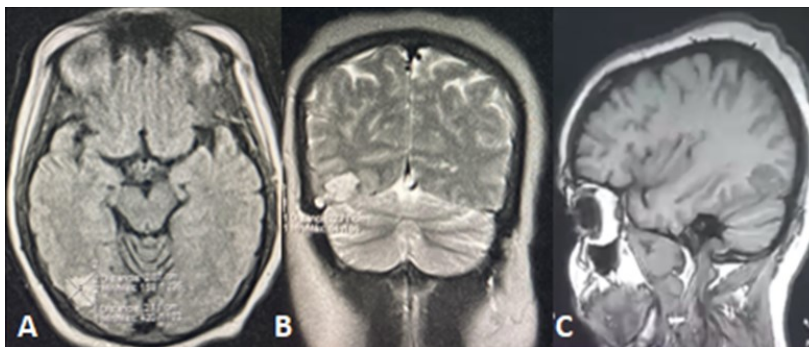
A: Simple skull MRI 0.35 T. Axial sections. FLAIR weighting. A hyperintense lesion of probable tumor etiology with irregular edges without mass effect or perilesional edema is observed in the right occipital region. B: Coronal cuts. T2 weighting. The hyperintense lesion described above is observed that rides over the tentorium cerebellum and is located in relation to the right transverse sinus. C: Sagittal sections. T1-weighted: The lesion described above is observed, but with a significant decrease in its intensity (hypointense) in supratentorial subcortical T1.
